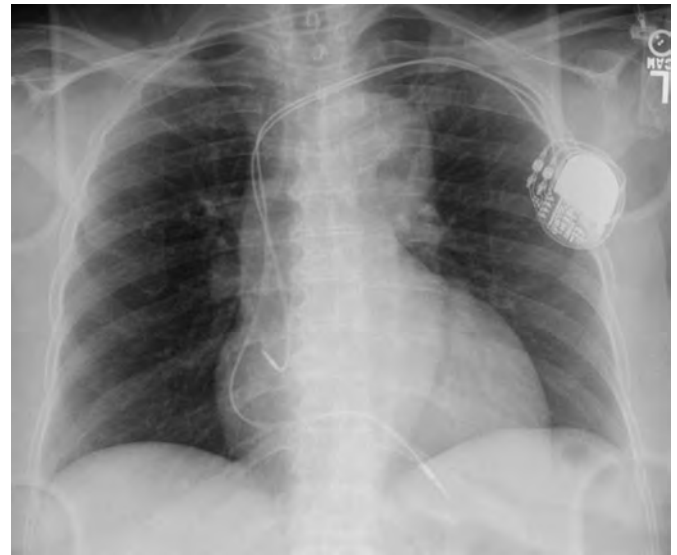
Supine frontal chest radiograph shows an example of a dual-chamber pacemaker with leads in the right atrium and right ventricle. Notice the difference between the pacing leads shown in this example and the shock coils of an implantable cardioverter-defibrillator located in the right atrium and right ventricle in Fig. 45.4.
